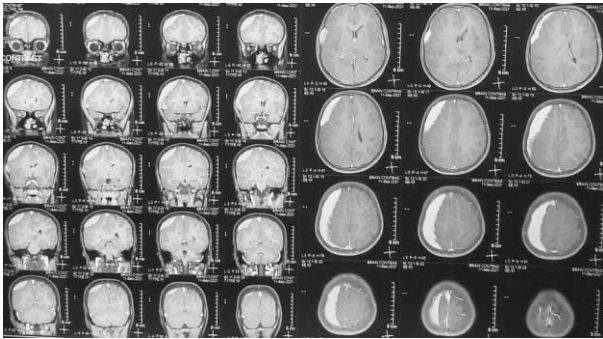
MRI Brain revealed chronic subdural haematoma in Right Fronto-temporo-parietal convexity with midline shift toward right side with cisternal effacement.
